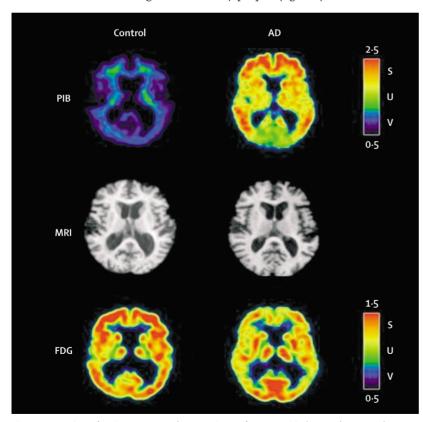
Comparison of PIB images, MRI, and FDG-PET images from a cognitively normal person and a patient with mild Alzheimer's disease
